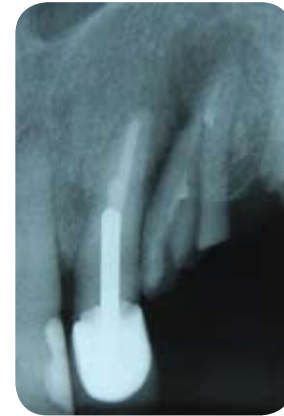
Radiograph of a fractured endodontically treated tooth at the base of the post on No. 10 and a perforation on tooth No. 11. How good is retreatment?
